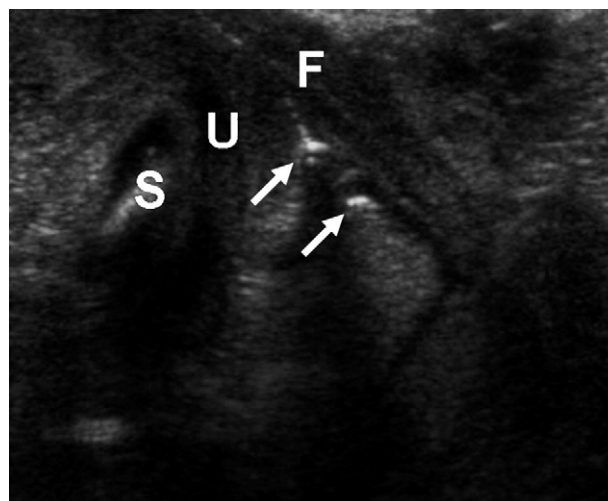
Midline sagittal ultrasonographic image of the perineum. The symphysis pubis (S) and urethra (U) are marked. Bubbles of air and meconium (arrows) passed down a channel to the posterior fourchette (F).
